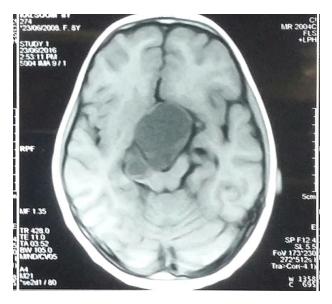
MRI Brain showing large craniopharyngioma
